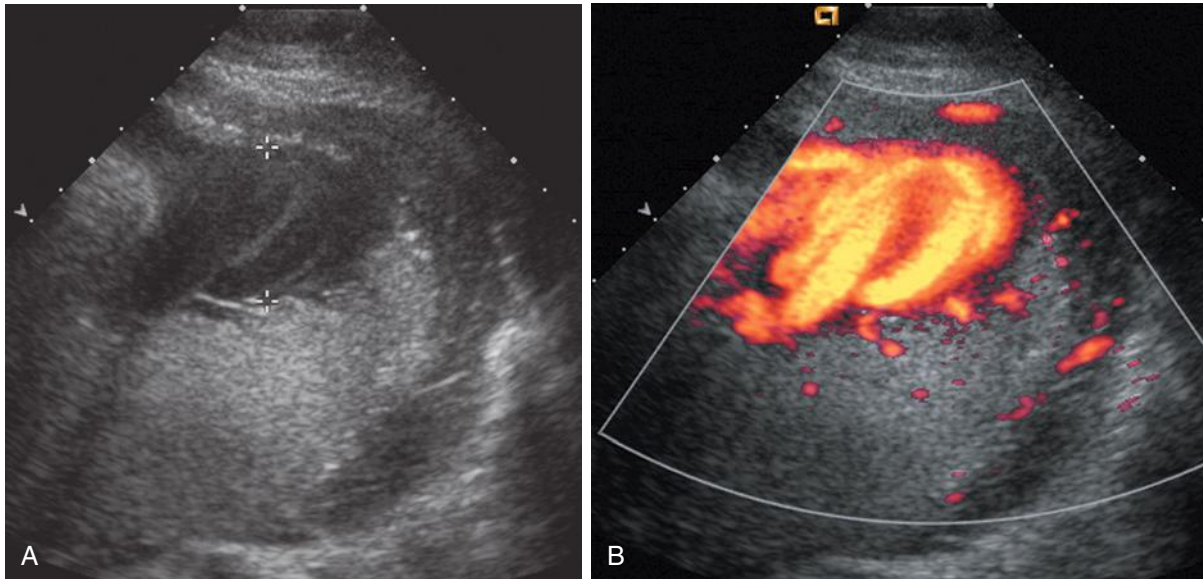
When amniotic fluid volume is assessed, the “pocket” of fluid should be free of umbilical cord. A, In this patient, there appears to be a 3-cm pocket of amniotic fluid (*calipers*). B, Doppler evaluation of this area revealed that this “pocket” was not amniotic fluid but all umbilical cord.
